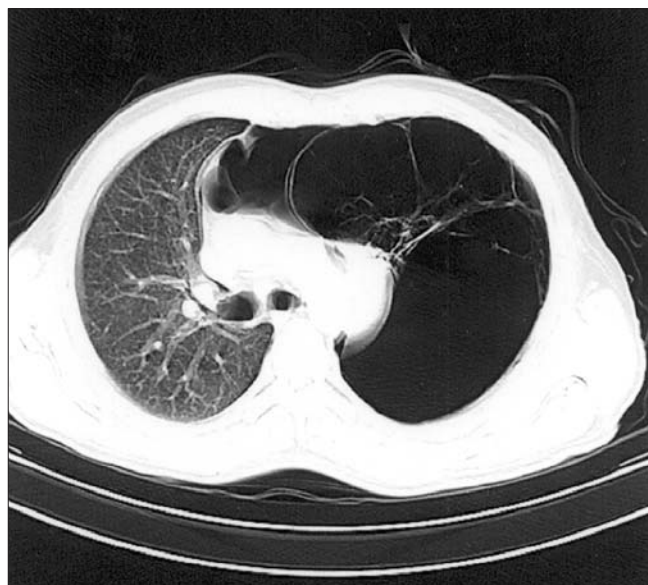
A contrast-enhanced CT scan of the patient's chest showing large emphysematous bullae on the left with a shift of the mediastinum to the right. The radiolucent spaces divided by contrast-enhanced lines are bullae with their associated septae.
